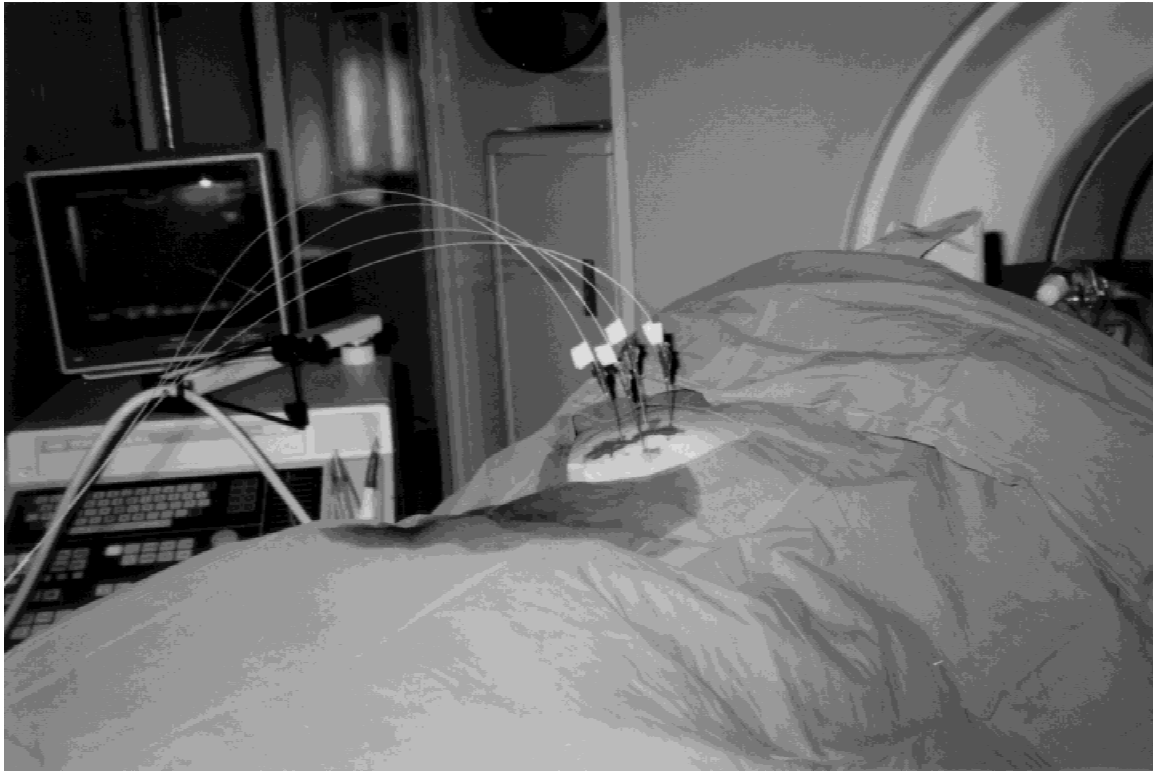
Patient with needles and laser fibres inserted percutaneously. The ultrasound and computed tomography machines are in evidence.
